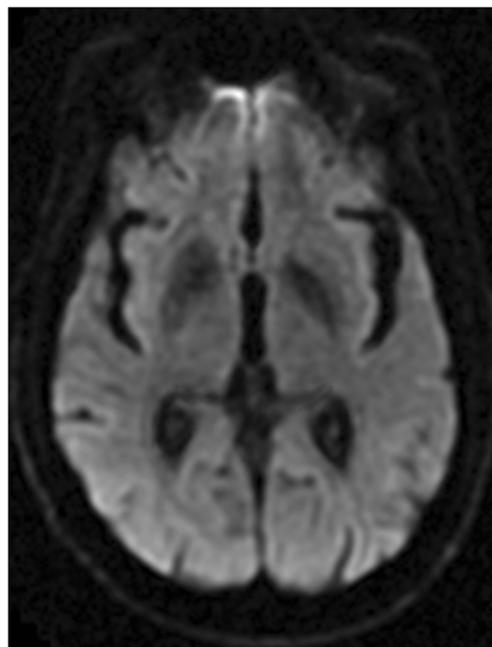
DWI shows no diffusion restriction in the basal ganglia
